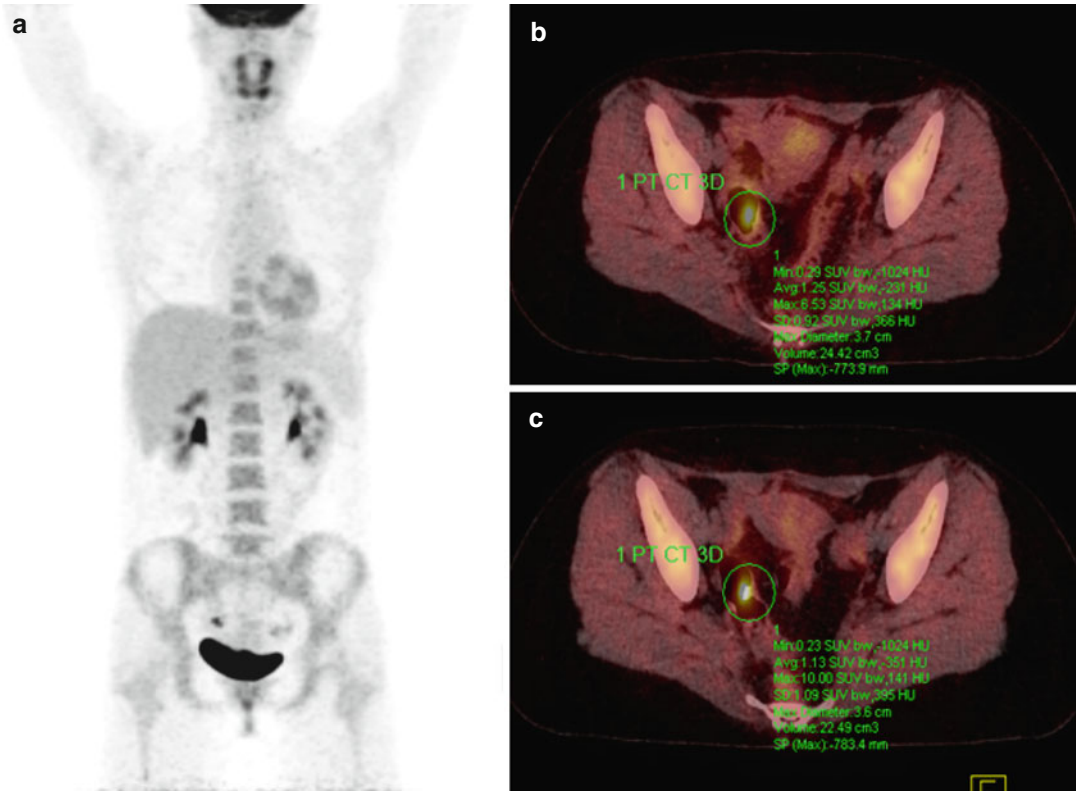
MIP-PET (a), PET/CT standard (b), and delayed (c) acquisition reveal hypermetabolic focus at the dolichosigmoid. SUVmax further increases in delayed acquisition
